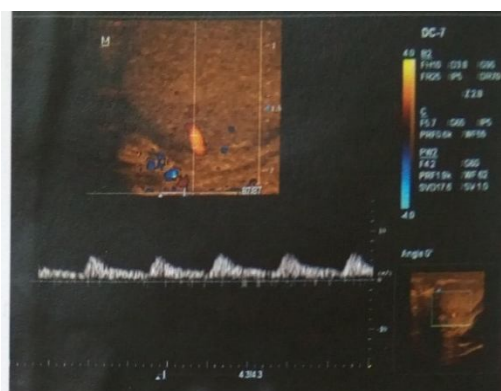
Postoperative Duplex ultrasound of a boy in group A, showing normal scrotal position of right testis which measures about 0.72 CC, had normal echo-pattern and normal tissue differentiation, uniform color saturation, normal biphasic Doppler flow wave of right testicular artery.
